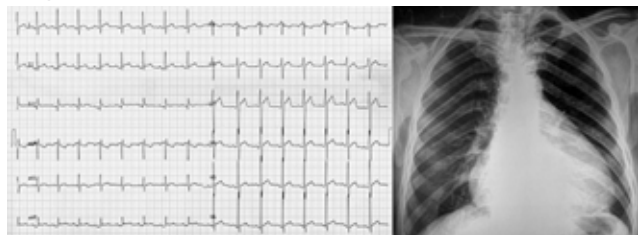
echocardiographically diagnosed pericardial effusion, and elevated C-reactive protein (CRP).
